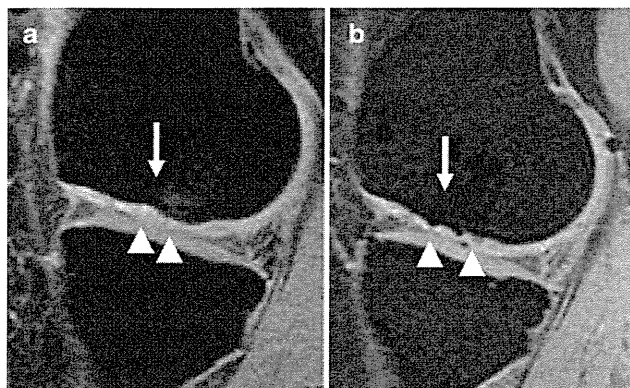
T1-weighted MRI with fat suppression after the surgery showed a smooth cartilage surface (*arrowheads*) and the same signal intensity of the grafted bone as the surrounding bone in the medial femoral condyle (*arrows*). a Sagittal image of the right knee. b Sagittal image of the left knee
